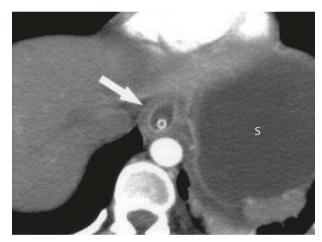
Axial computed tomography at the esophagogastric junction level shows edematous thickening and enhancement of the distal esophageal wall (white arrow). Submucosal esophageal tear was confirmed at surgery.
